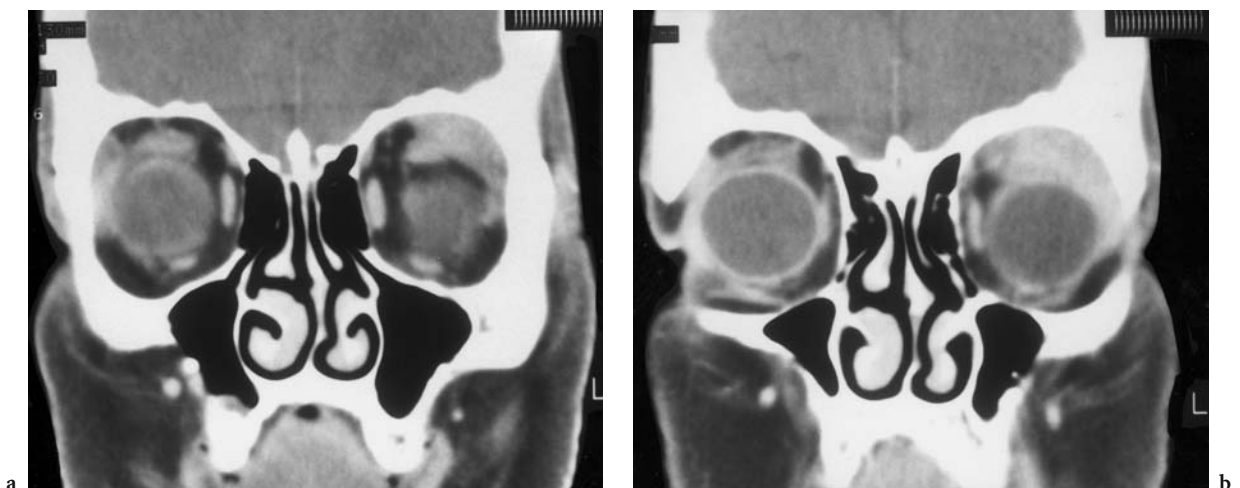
A 68-year-old woman with slowly progressing dislocation and protrusion of the left globe. Diagnosis: epithelioid-cell granuloma in the course of a sarcoidosis. CT: a Coronal view of the posterior globe, b Coronal view at the lacrimal fossa. Both images demonstrate the sharply defined, homogeneous, extraconal tumor with posterior expansion, covering and slightly depressing the globe
